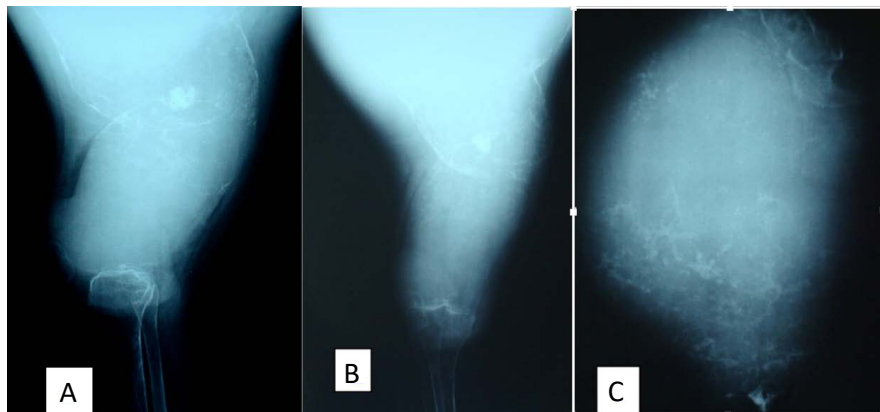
X-ray of the right thigh, side (A) and front (B and C), showing the significant heterogeneous osteolysis of the femur and the sequestrations giving the lesion a "cloudy appearance".
